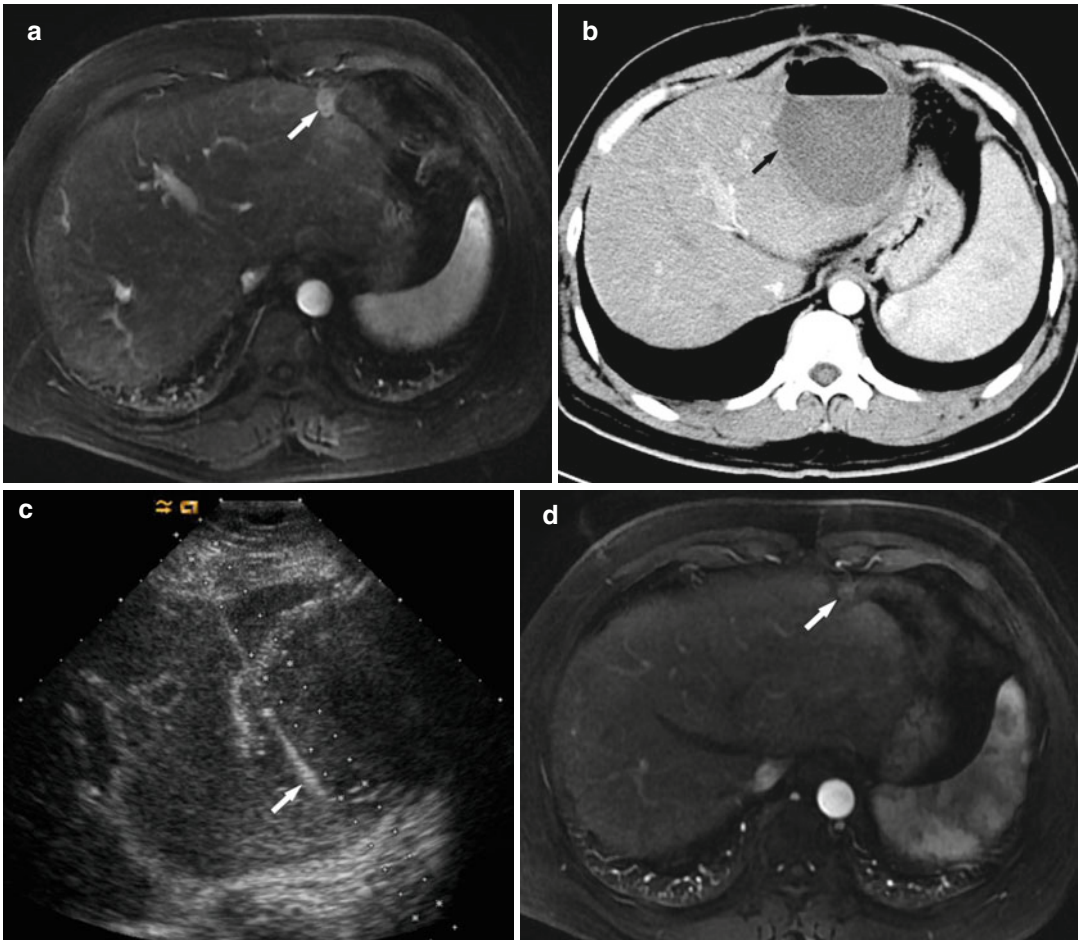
Hepatic abscess in a 42-year-old man with liver metastasis from rectal cancer. (a) Contrast magnetic resonance imaging obtained before ablation showed a moderate enhancement of the nodule in the left lateral segment with the size of 1.6×1.2 cm (white arrow). (b) Follow-up
